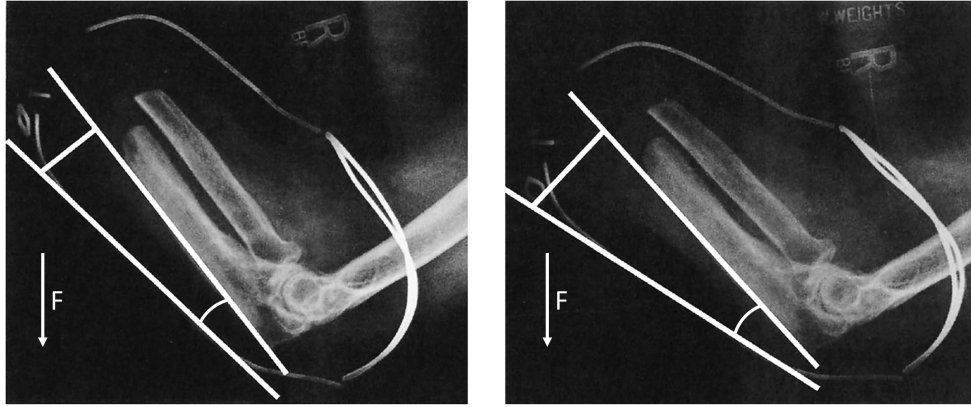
An X-ray of a trans-radial residuum inside of a Münster socket, one of the first self-suspending trans-radial prosthetic socket designs. The letter ‘F’ represents the direction of loading. (a) Shows the limb without distal loading. (b) Shows the limb with distal loading. Note how the angle between the socket wall and the residual radius and ulna has increased at the distal end. Image modified from [39].
